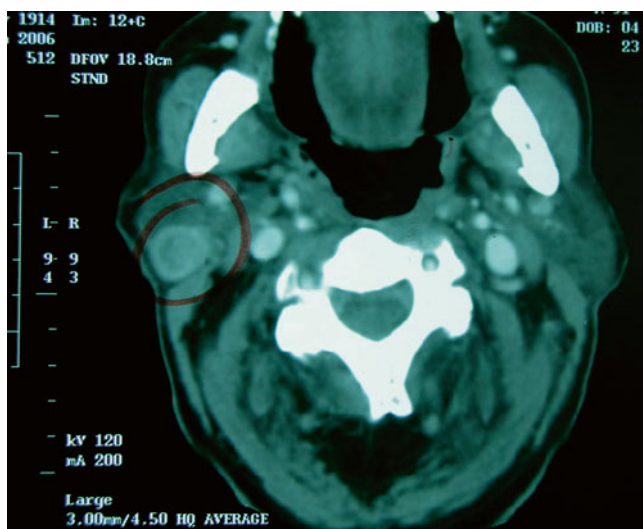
CT scan administered with intravenous contrast highlighting (*black marker pen*) a 2 cm metastatic node located within the posterior aspect of the right inferior parotid gland. Note the contrast enhancement of the circular node with central hypodensity present consistent with necrosis. These are all radiological features typical of a metastatic node containing cutaneous squamous cell carcinoma
